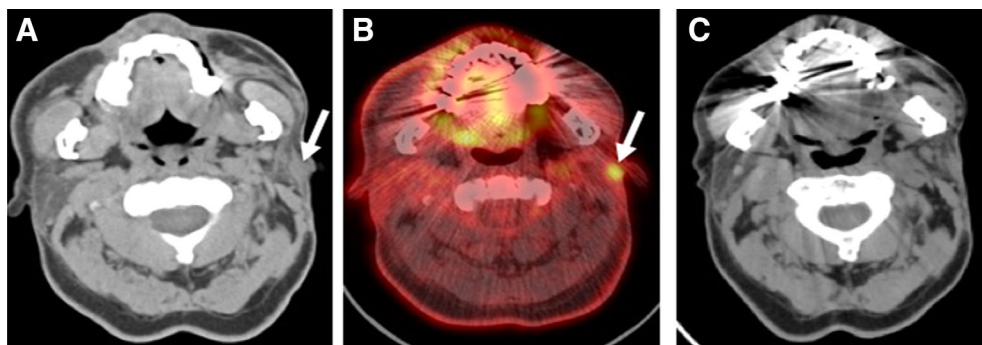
Radiological course of lesion in the first case. Axial unenhanced computed tomography (CT) image at baseline (A) shows a left cervical superficial soft tissue nodule that was fluorodeoxyglucose-avid on subsequent positron emission tomography/CT (B). This nodule resolved on follow-up CT (C).
